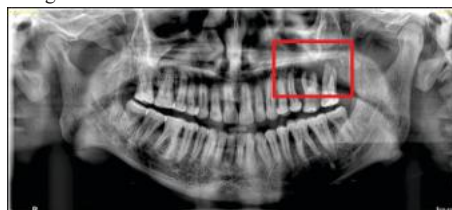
Orthopantomogram Reveals Complete Alveolar Bone Loss Around 26 and 27 Exhibiting Floating Tooth Appearance.
